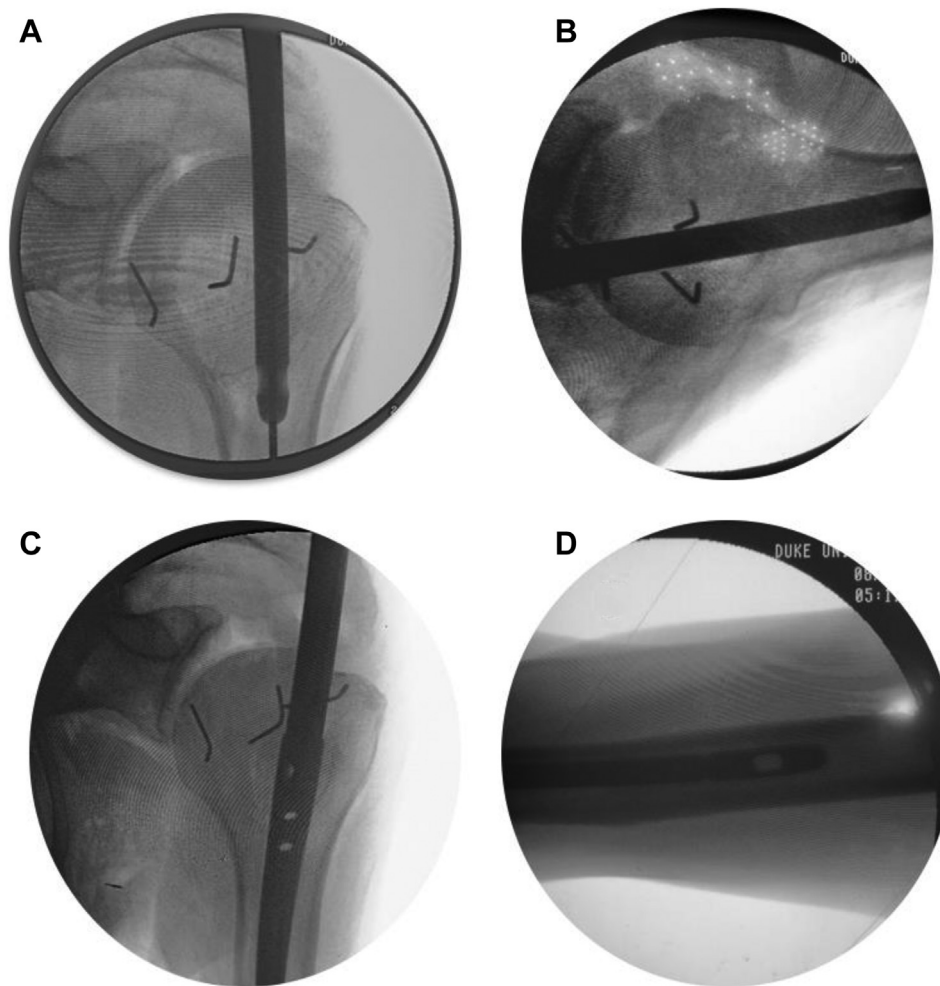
Radiographic images of humeral nail placement: anteroposterior view of humeral nail insertion (A), lateral view of humeral nail insertion (B), anteroposterior view of proximal humeral stem (C), and lateral view of distal end of humeral nail (D).
